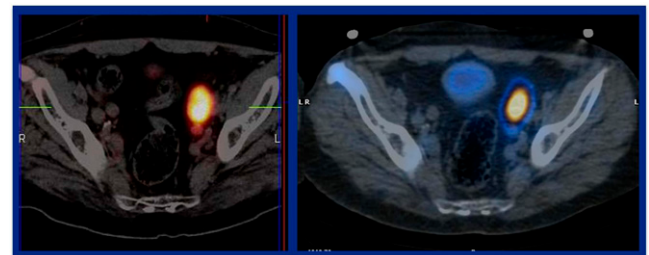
Prostate-specific membrane antigen (PSMA) imaging with technetium. $^{99\text{m}}\text{Tc}$ -PSMA/CT (right) and ^{68}Ga -PSMA/CT (left) images were compared in individuals with PSA levels ranging from 0.13 to 270 ng/mL. Agreement between ^{68}Ga -PSMA and $^{99\text{m}}\text{Tc}$ -PSMA imaging was moderate. In institutions without a PET/CT facility or ^{68}Ga generator, $^{99\text{m}}\text{Tc}$ -PSMA appears to be feasible provided that SPECT (preferably SPECT/CT) is available.
